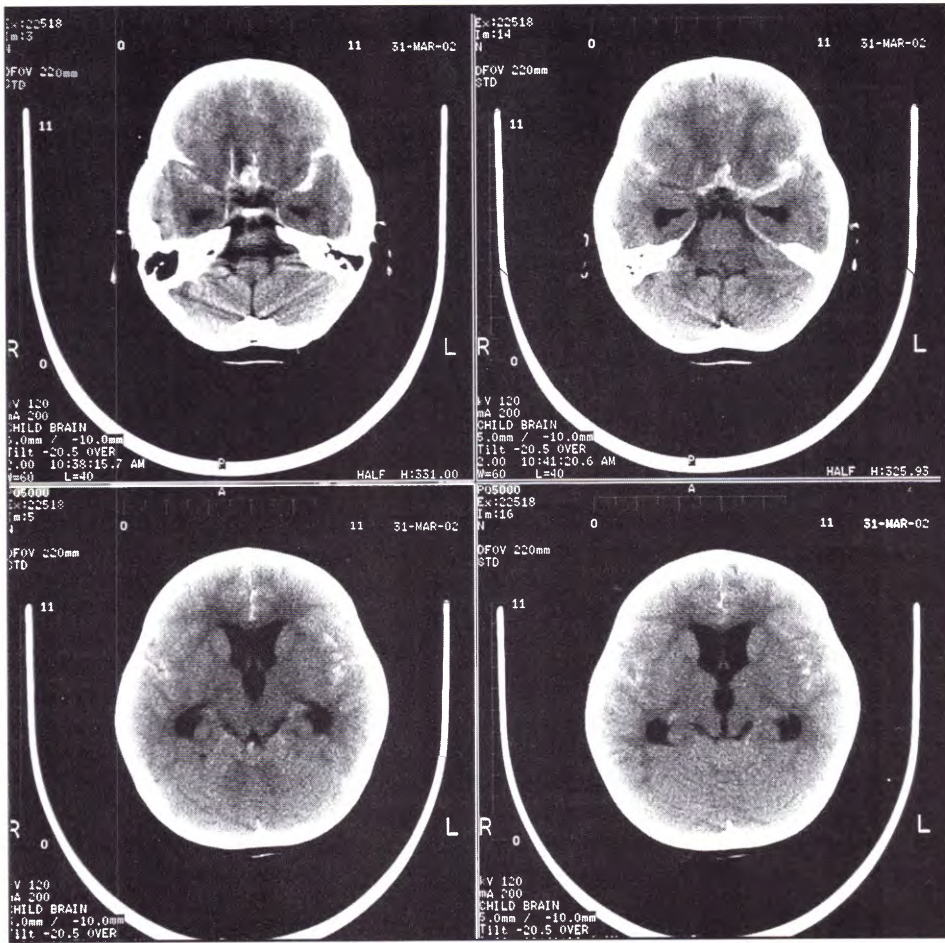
Admission CT: subarachnoid hemorrhage and ventriculomegaly
